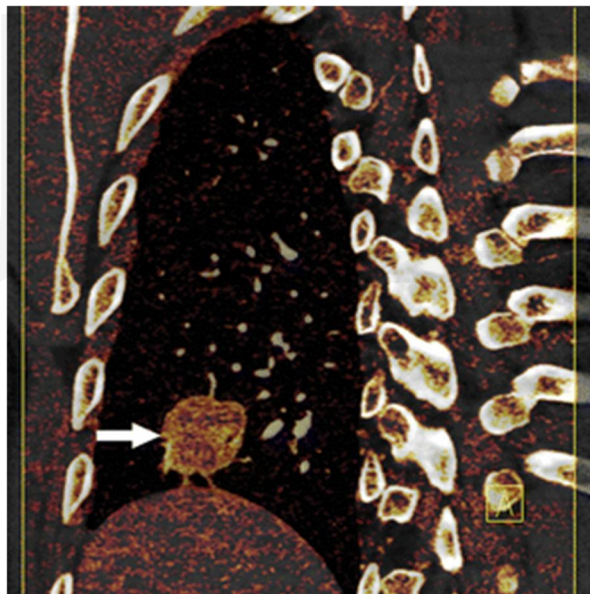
Dual-energy CT (DECT) study of 45-year-old man with lung adenocarcinoma in right lower lobe. Images were derived from dual-source CT-based DECT study of lungs. B, Axial (A), coronal (B), and right sagittal (C) fused display images show irregular pulmonary nodule (*arrows*) with moderate enhancement in right lower lobe.
